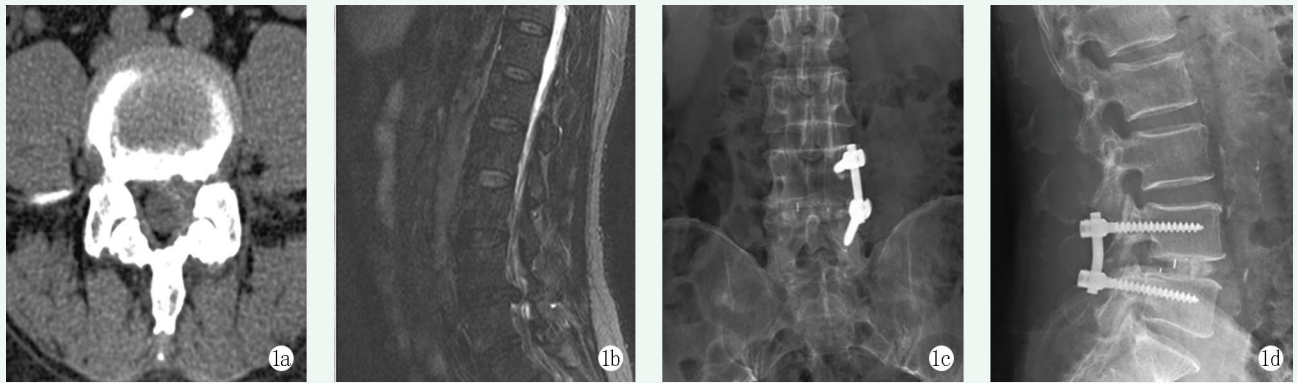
患者男性, 55 岁, 反复腰痛 4 年, 伴左下肢放射痛 3 个月余, 诊断为 $L_{4/5}$ 椎间盘突出症, 行单侧椎弓根钉棒内固定 PLIF。1a, 1b: 术前腰椎 MRI 显示 $L_{4/5}$ 椎间盘突出症; 1c, 1d: 术后腰椎正侧位 X 线片显示融合器及椎弓根钉棒位置良好。
